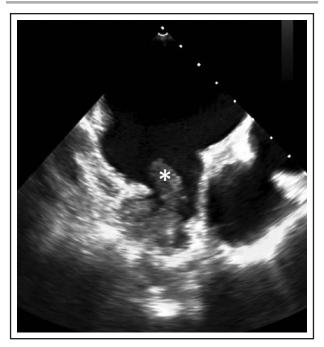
Example of a thrombus (*) in the left atrial appendage on transesophageal echocardiography.
